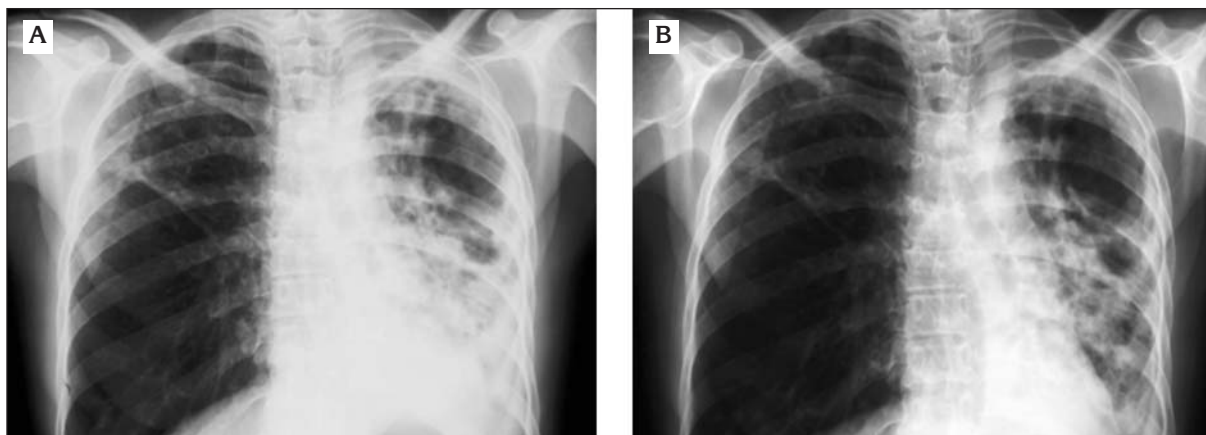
a. Chest X-ray at the admission revealed nodular infiltrates on the lower lung zone of the left lung. 1.b. Radiological improvement after the therapy.
